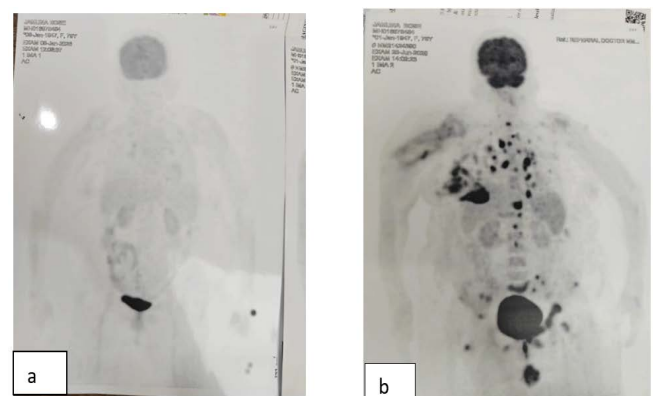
Baseline and follow-up PET-CT images in Case 1 showing marked metabolic response after tucatinib plus T-DM1.
